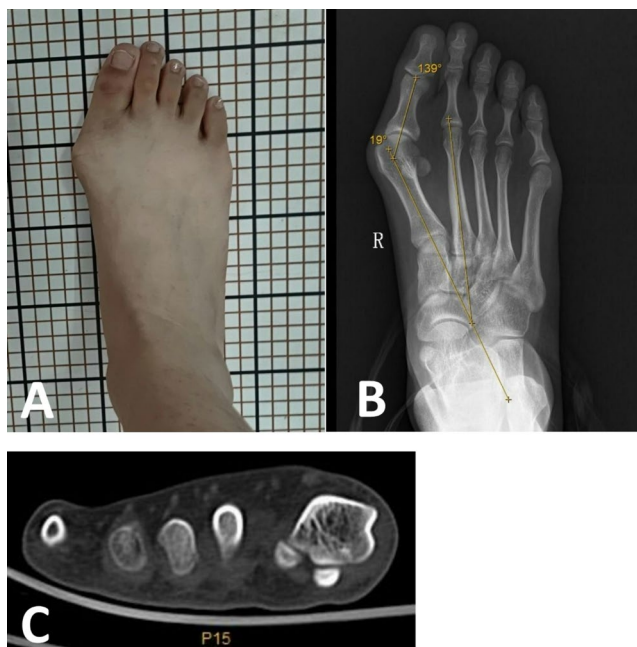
A 18-year-old female patient with a severe HV deformity. A Preoperative appearance of the right foot. B Preoperative weight-bearing X-ray image showing a severe hallux valgus deformity of the right foot. The HVA was 41°, the IMA was 19°, and the TSP was 4. C CT image showing pronation of the first metatarsal
